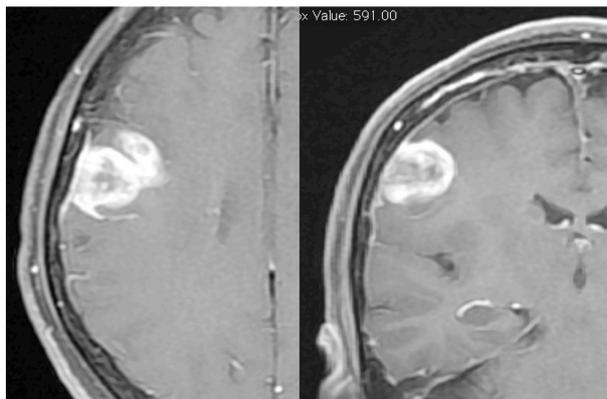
Magnetic resonance image of the patient's tumor before BNCT. The tumor located superficially in the parietal convexity with peripheral low density rim.
